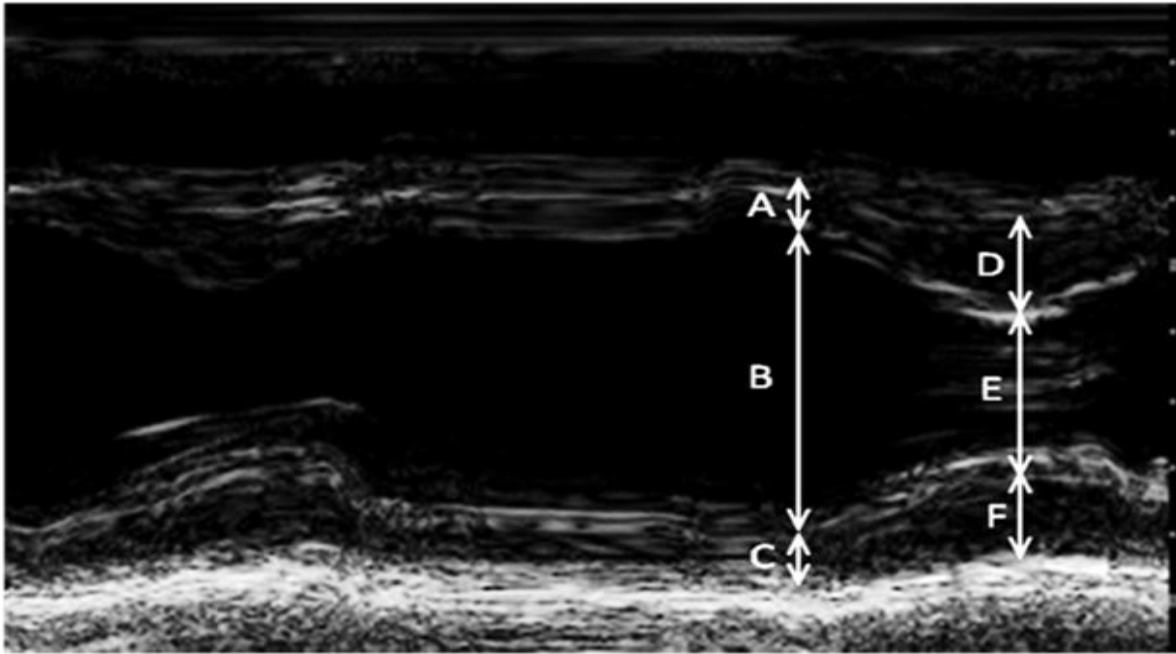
Two Dimensional M-mode guided echocardiographic image to assess LV dimensions. A is interventricular septal wall thickness in diastole, B is left ventricular end diastolic diameter, C is posterior wall thickness in diastole, D is interventricular septal wall in systole, E is left ventricular internal diameter in systole, and F is posterior wall thickness in systole
